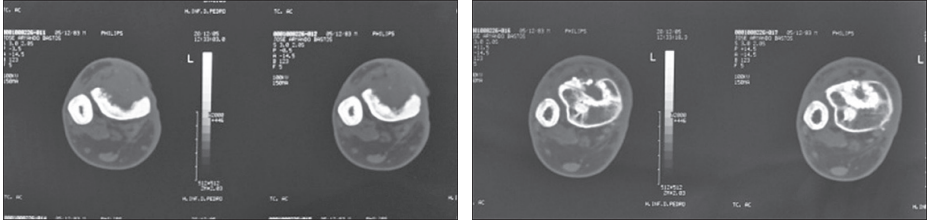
CT Scan details
